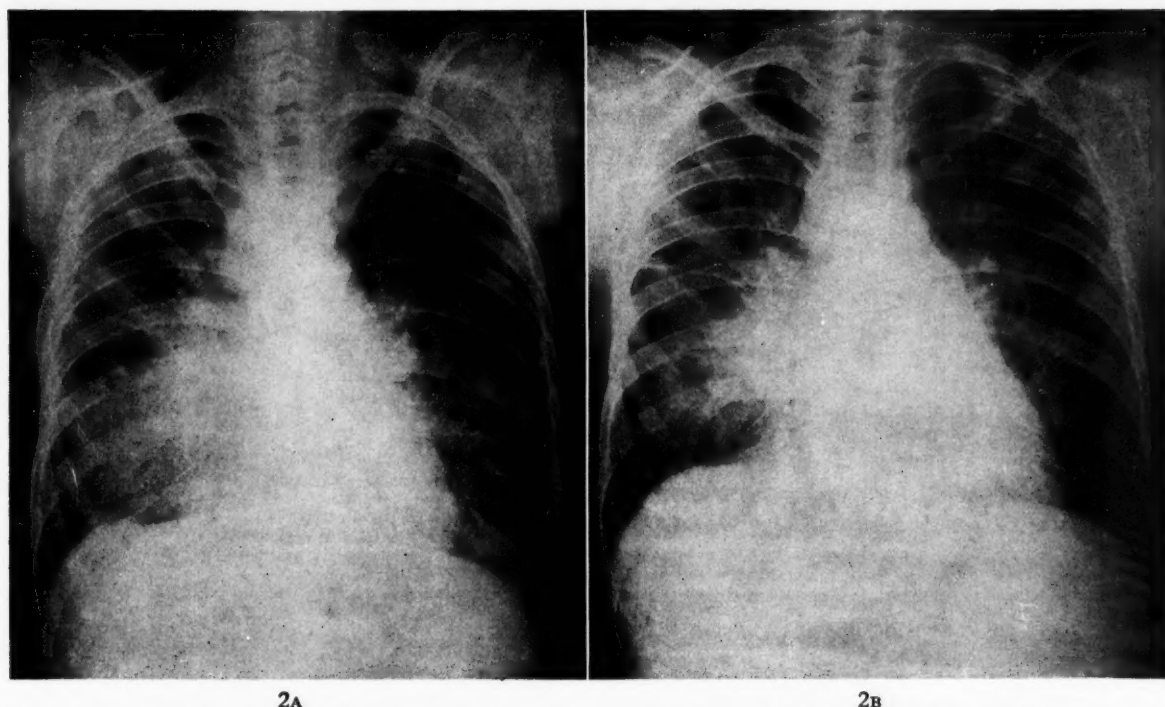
A, x-ray of the chest of E. H., Case II, with pulmonary granulomatosis of unknown etiology before treatment with cortisone; B, x-ray of chest of same patient after treatment with cortisone.
